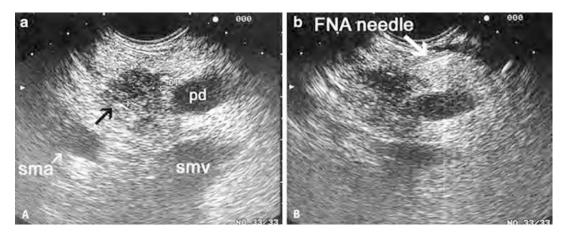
Endoscopic Ultrasound. (a) The tumor (*black arrow*) is clearly visualized, as well as its relationship to the superior mesenteric artery (sma) and vein (smv). (b)
